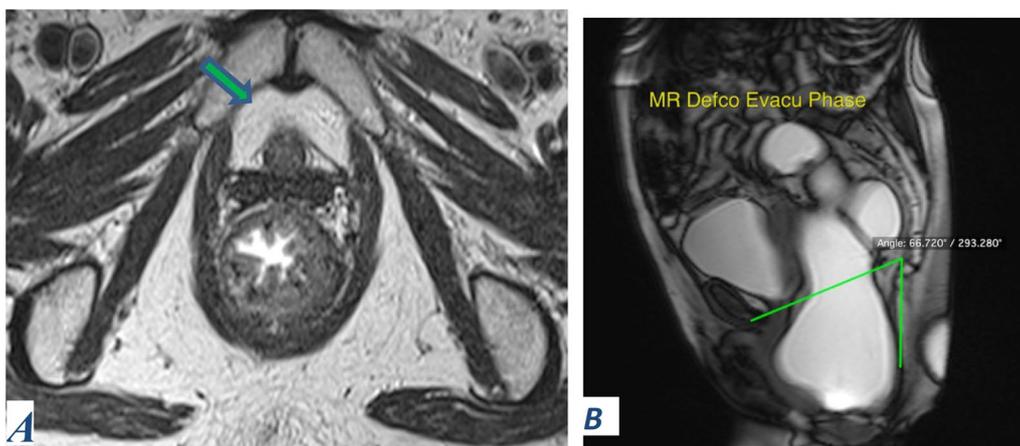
A 51-year-old woman with 1st presentation of stress urinary incontinence showing: A Static axial T2-weighted TSE MR image showing the “drooping moustache sign,” due to level III endopelvic fascial defect (green arrows). B Sagittal dynamic image of the same patient showing increased LPA denoting pelvic floor muscle weakness (the levator plate angle, is defined as the angle enclosed between the pubococcygeal line and the levator plate (green line))
